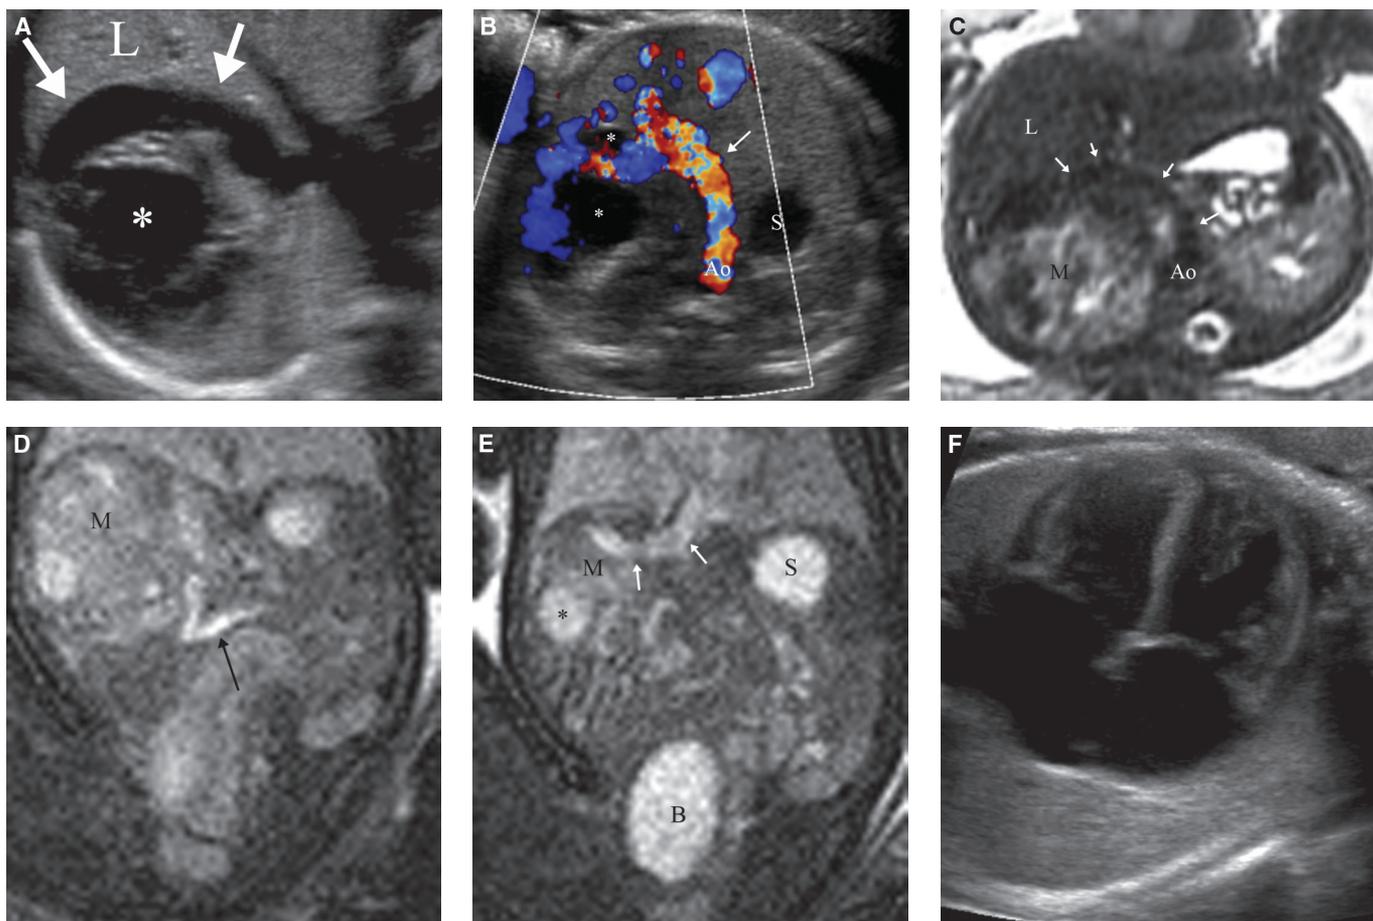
Hepatic hemangioma. A: Axial US image of the right lobe of the liver (*L*) demonstrates a heterogeneous, predominantly hypoechoic mass with a large round anechoic area centrally (*asterisk*) and a tubular anechoic structure anteriorly (*arrows*). B: Doppler confirms that the tubular structure is a large celiac and hepatic artery (*arrow*) arising from the aorta (*Ao*). There is no Doppler flow in anechoic cystic areas (*asterisks*) of degeneration. *S*, stomach. C: Axial MR T2w image demonstrates the heterogeneous, predominantly hyperintense mass (*M*). The tubular hypointense flow void of the large artery (*arrows*) is displaced by the mass. Coronal SSFP images demonstrate (D) the large feeding artery (*arrow*) supplying the heterogeneous hepatic mass (*M*) and (E) large hepatic vein drains into the IVC (*arrows*). *S*, stomach; *B*, bladder; *asterisk*, cystic degeneration. F: Four-chamber heart view demonstrates cardiomegaly secondary to high-flow shunt. (Courtesy of Chris Cassidy, MD.)
